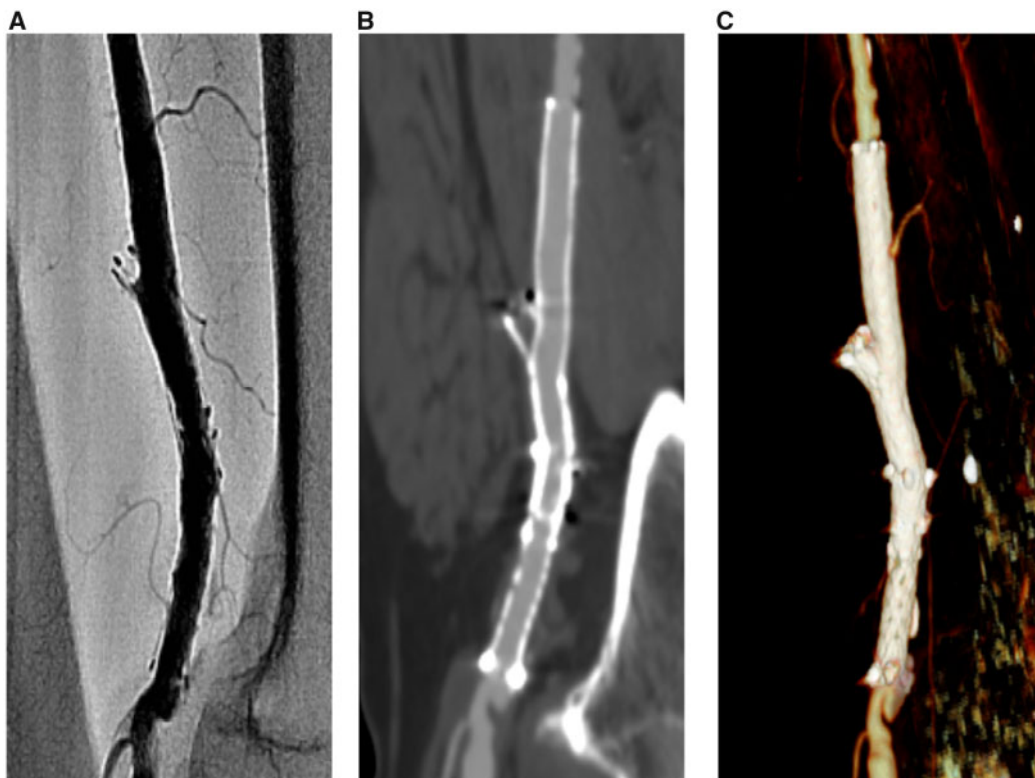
Final angiogram after procedures and follow-up computed tomography angiogram. (A) The final angiogram after procedures shows adequate stent expansion. (B) Follow-up computed tomography angiogram demonstrates stent patency. (C) The 3D reconstruction image of the computed tomography angiogram clearly shows that the proximal part of the fractured stent is located outside the vessel wall.
